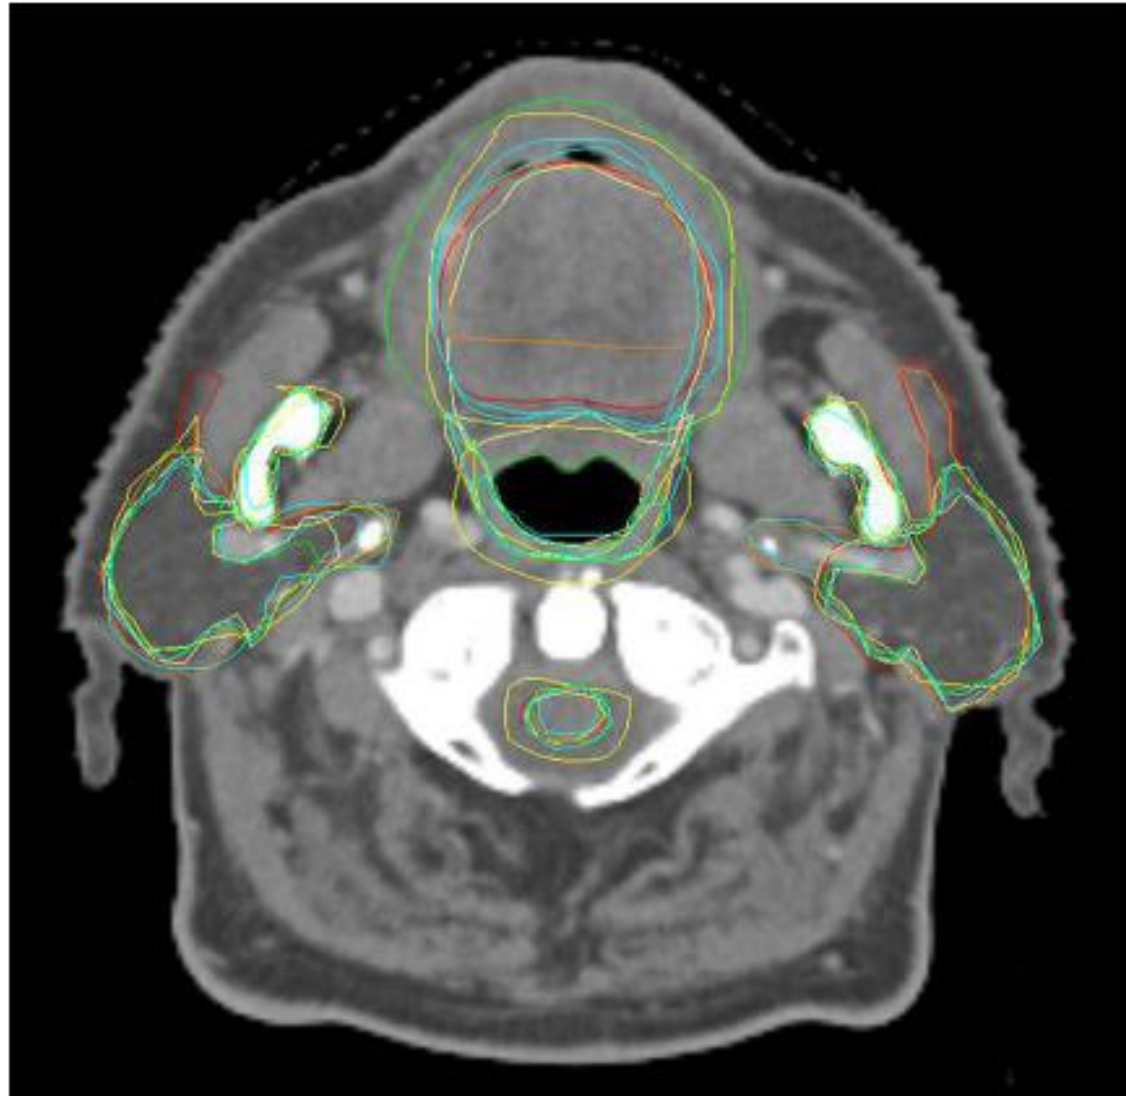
Delineation results of 7 members of the panel for the parotid glands, spinal cord, pharyngeal constrictor muscles and the oral cavity, projected on an axial CT slice.
